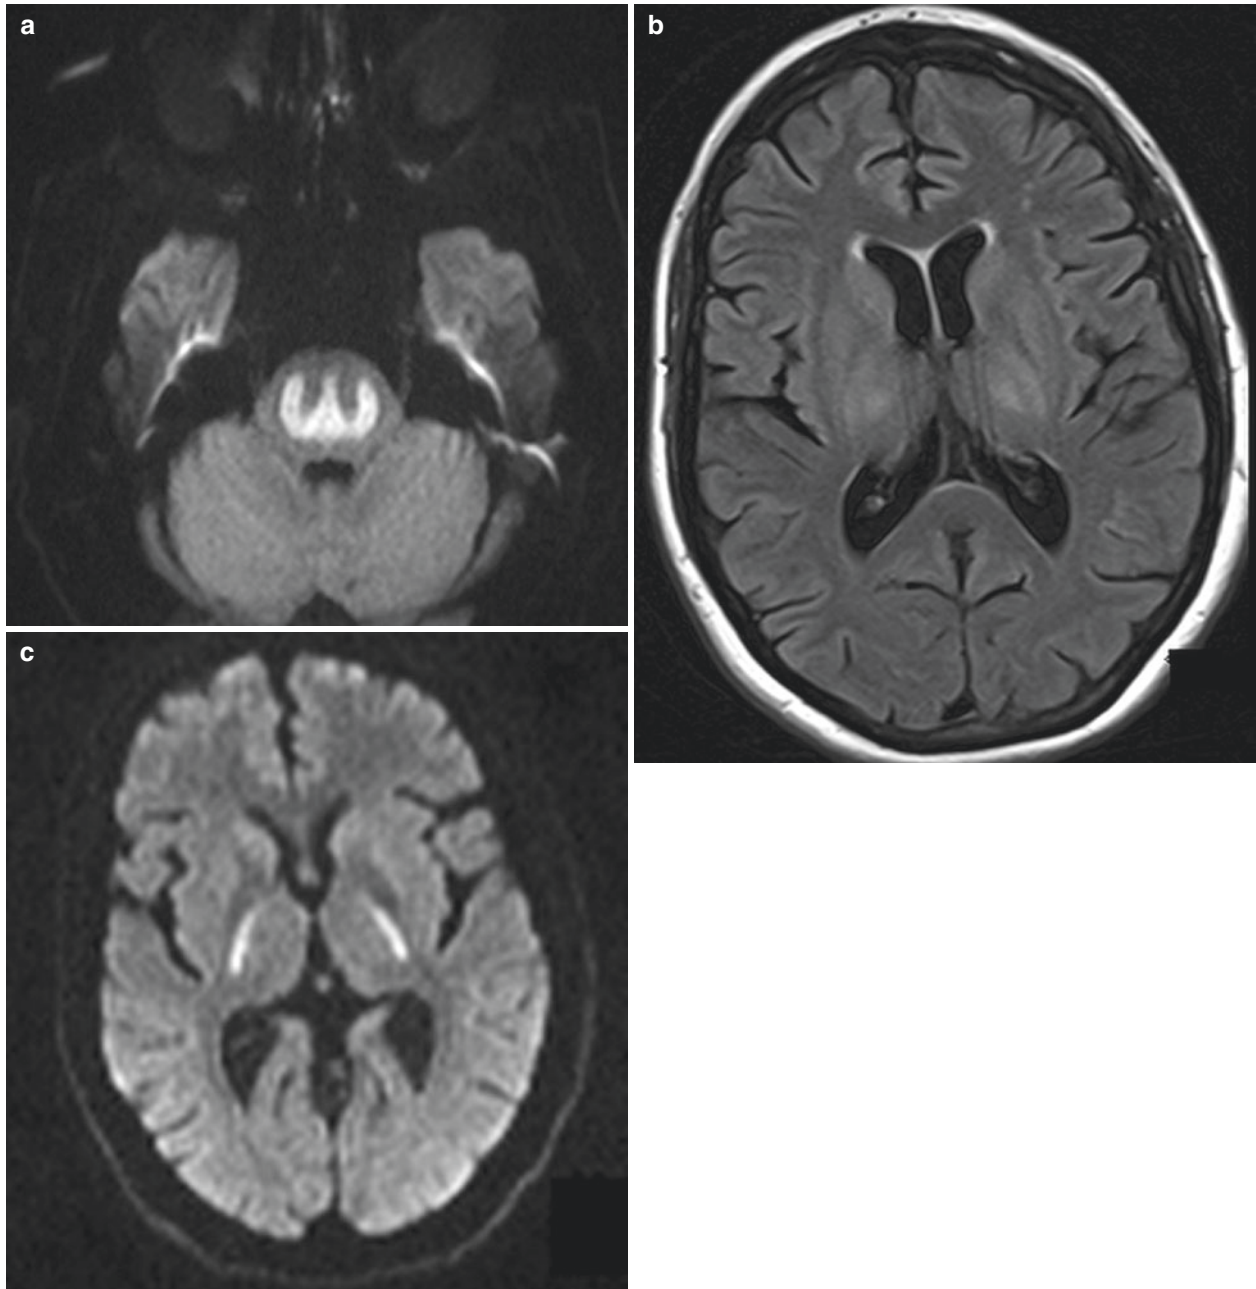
Osmotic demyelination syndrome. (a), patient with acute central pontine myelinolysis. Axial DWI shows diffusion restriction of the pons sparing the peripheral fibers and corticospinal tracts with a classic “trident” pattern. (b), A different patient with pontine and extrapontine
